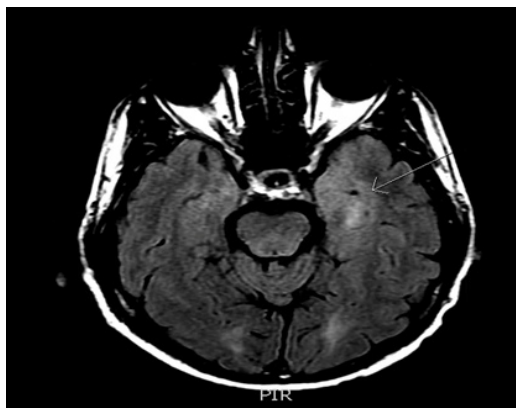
High FLAIR signal intensity within the medial aspect of the left temporal lobe.
